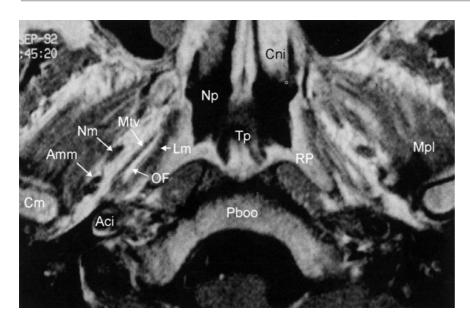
T1-weighted MR image through the nasopharynx. Np = nasopharynx, Tp = pharyngeal tonsil, Cni = inferior turbinate, Mtv = tensor veli palatini muscle, Nm = mandibular nerve, Amm = middle meningeal artery, Cm = mandibular condyle, Aci = internal carotid artery, OF = Ostmann fat pad, Lm = medial lamina of tubal cartilage, RP = pharyngeal recess, Mpl = lateral pterygoid muscle. Male 35 years of age with no otologic disease.
